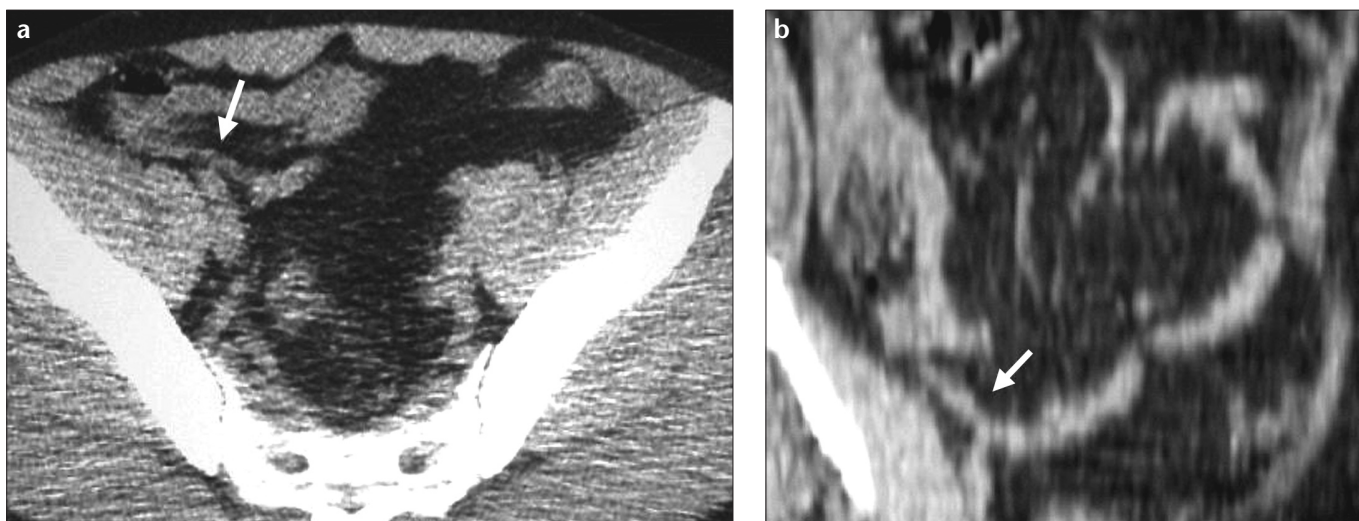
Axial CT section (a) and coronal-oblique MIP image (b) show pelvic position of the appendix. Axial image shows that root of the appendix and ileocaecal valve are located at the same level.
